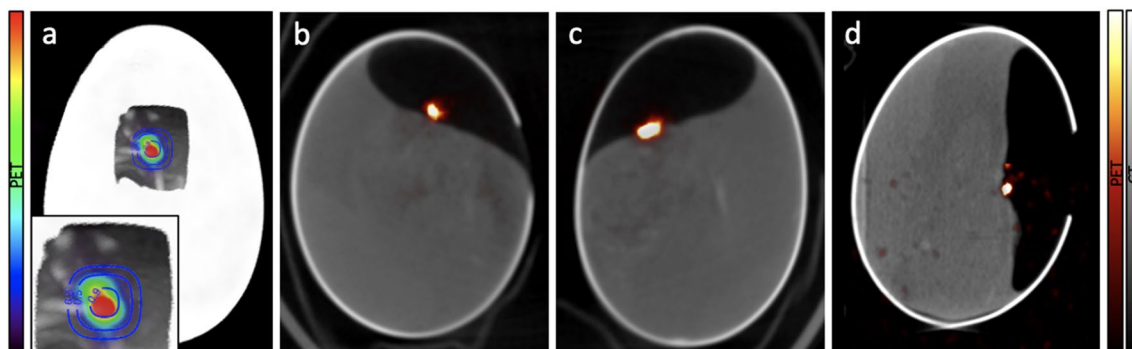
(a) Overlay of an estimation of the isodose contours of the delivered dose, the CT and the PET activation for E1. A zoomed image of the irradiated area is shown in the insert. Fused PET and CT images obtained for E1 (b), E2 (c) and E3 (d).
